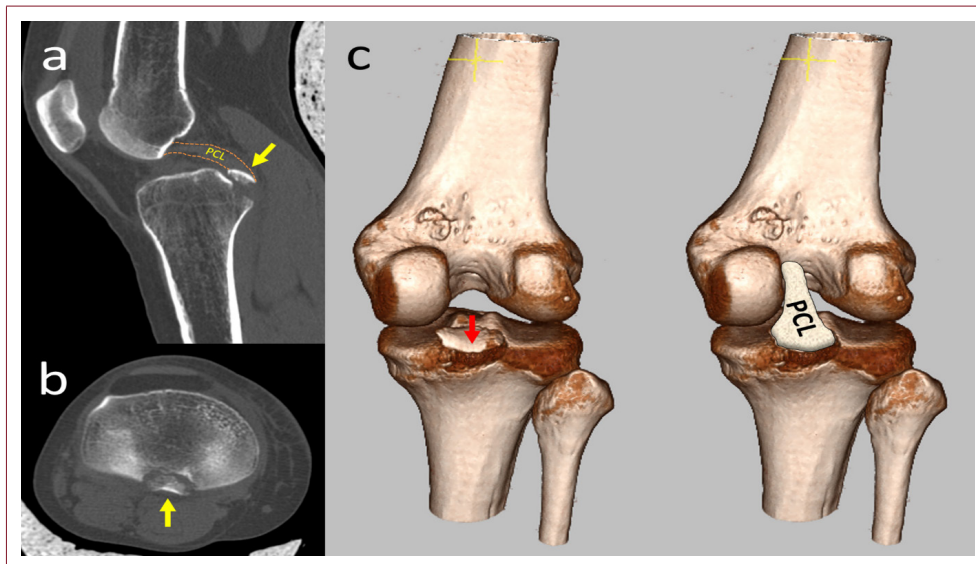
Typical preoperative CT scans showing an avulsion fracture of the tibial posterior cruciate ligament (PCL).
